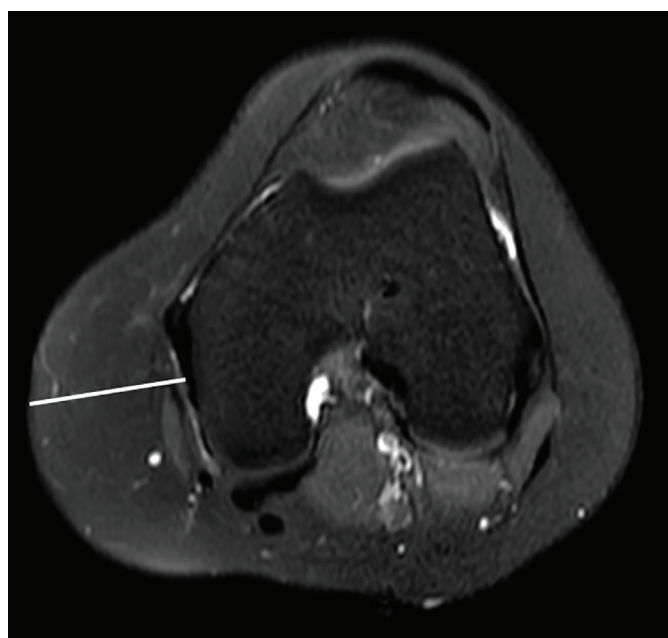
Measurement of subcutaneous fat thickness. Axial T2-weighted MRI of the knee demonstrating measurement of the subcutaneous fat thickness on the medial aspect of the knee joint at the level of the medial femoral condyle
